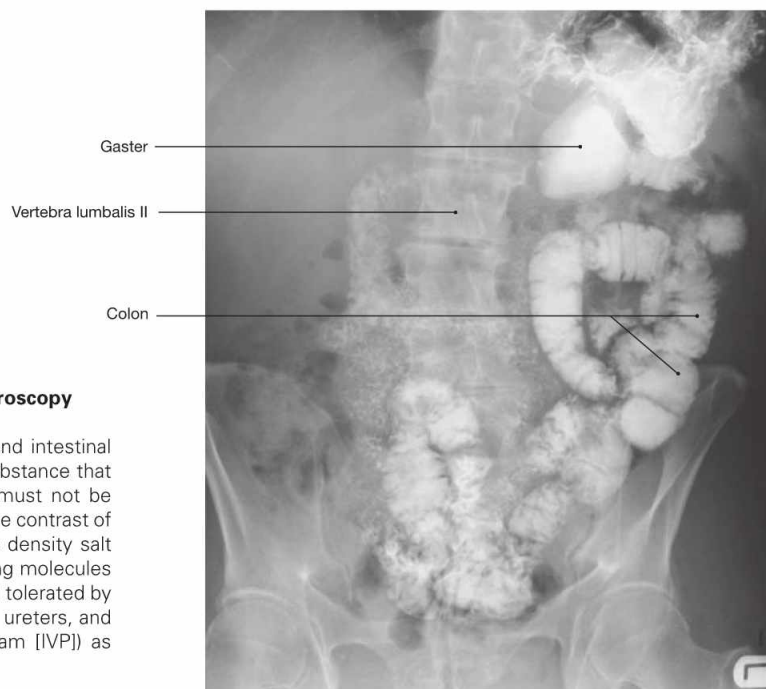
Conventional radiograph (X-ray), colon fluoroscopy after barium swallow test. [8]
